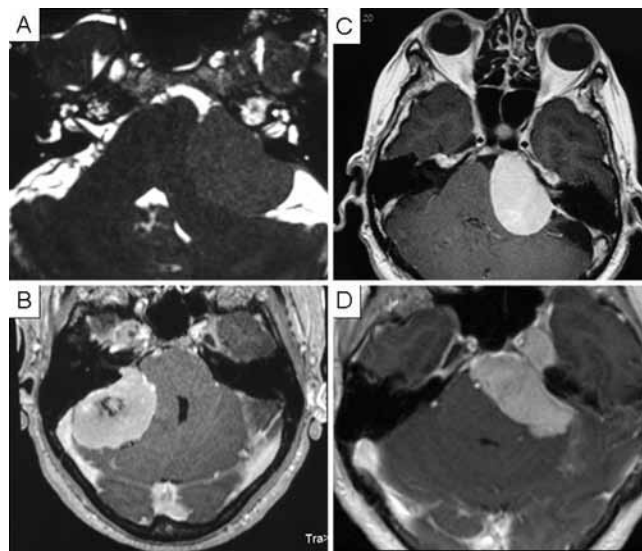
Axial MR images showing the radiological classification of posterior petrous bone meningiomas. A: Left-side Type M meningioma. B: Right-side Type P meningioma with extension into the IAC. C: Type A meningioma with extension into the IAC. D: Type A meningioma with multiple extensions into the clivus and Meckel cave.
